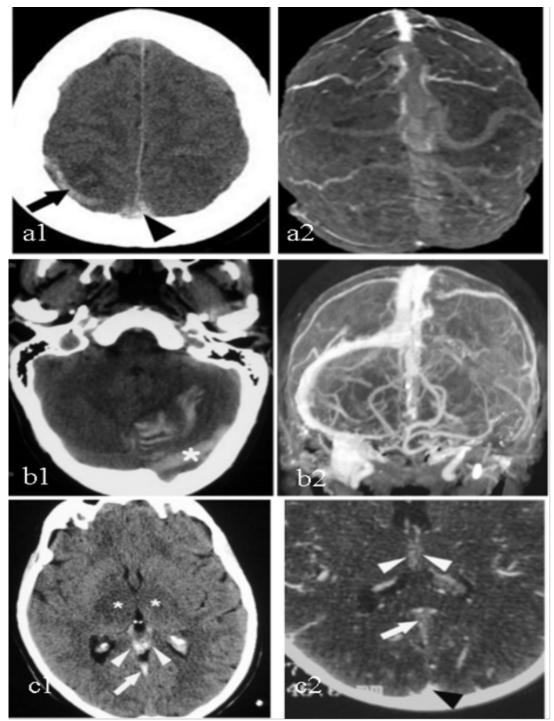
a1. CT Venography showing Thrombosis of the superior sagittal sinusin a 21-year-old woman. Axial unenhanced CT images with a "dense triangle" sign (arrowhead) and a cord sign (arrow), findings suggestive of sinus and cortical vein thrombosis, a2. 3D integral image from CT venography (posterosuperior view) shows filling defects in the superior sagittal sinus and parietooccipital veins, an appearance indicative of thrombosis. b1. Thrombosis of the left transverse sinus in a 43-year-old woman. Axial unenhanced CT images with increased attenuation in the left transverse sinus (cord sign). B2. 3D MIP image from CT venography, the left transverse sinus is not visible. Findings suggestive of left transverse sinus thrombosis. c1. Deep cerebral venous thrombosis in a 40-year-old woman. Axial unenhanced CT image shows an area of low attenuation in both thalami (*) associated with increased attenuation in the straight sinus (arrow) and internal cerebral veins (arrowheads). C2. Axial contrast-enhanced CT image shows filling defects in the straight sinus (arrow) and internal cerebral veins (arrow) and internal cerebral veins (white arrowheads), an appearance consistent with thrombosis. The normally enhancing superior sagittal sinus (black arrowhead).
